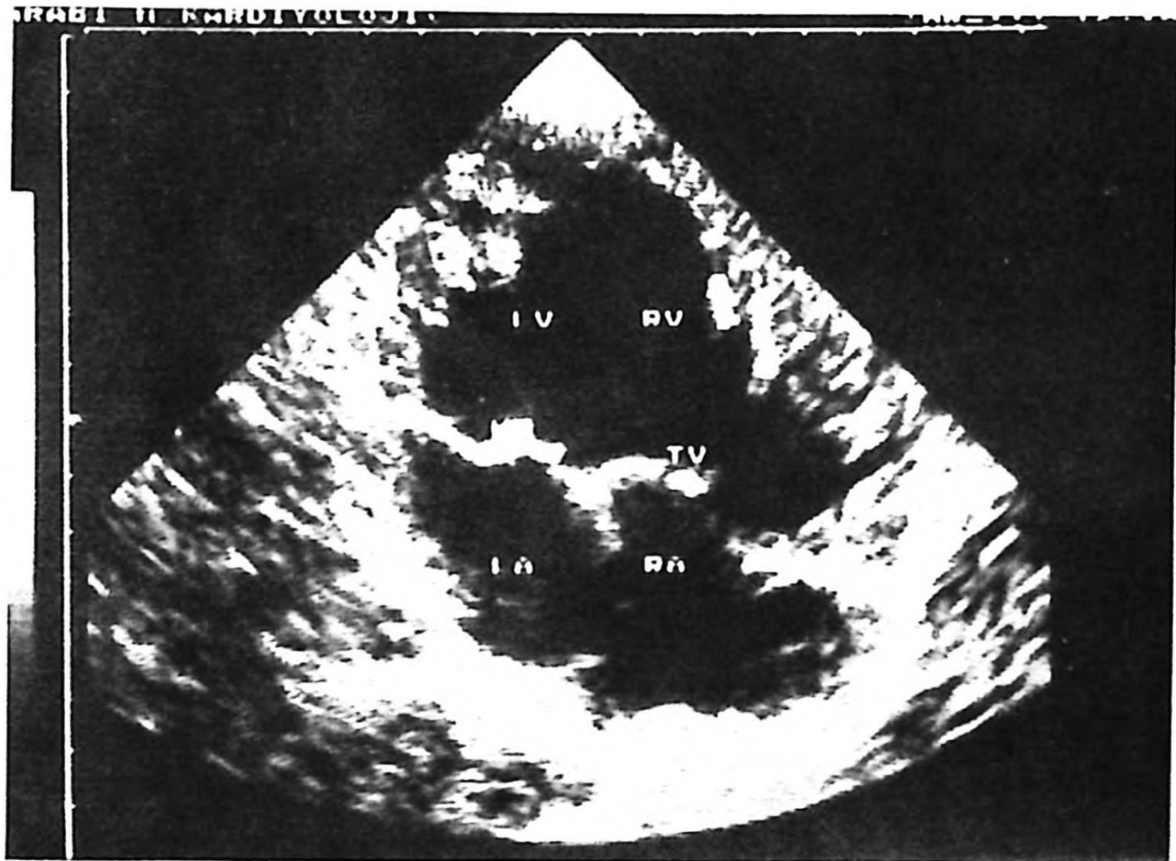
Echocardiogram of Case 1 showing absence of the ventricular septum.
